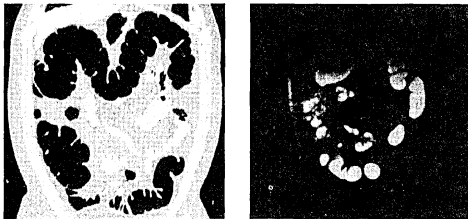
Images acquired with CT (left) and MRI (right)
